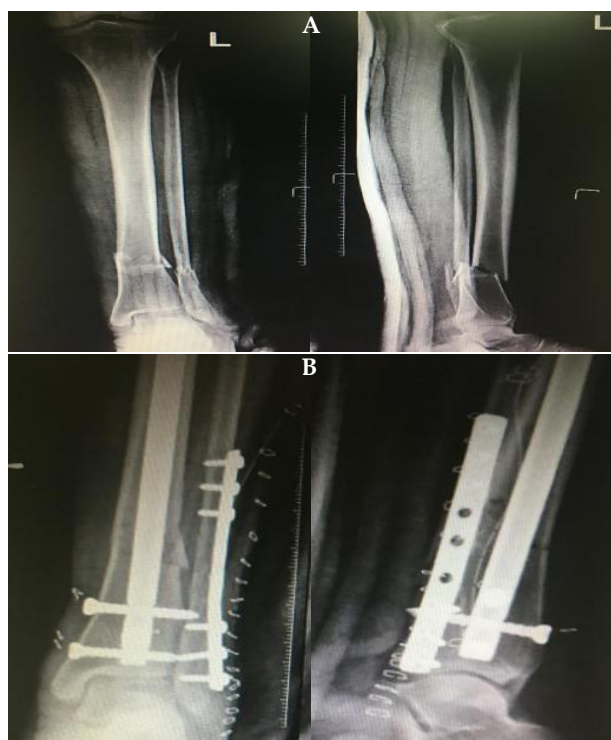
A: pre-op X-ray left leg AP view and lateral view. B: post-op X ray left leg AP view and lateral view.
